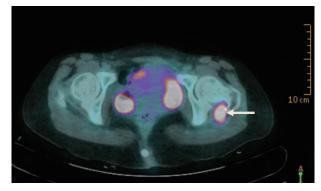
PET/CT showed a high FDG uptake nodule adjacent to left femoral neck (SUV max early: 9.5, delay: 11.4) (arrow).
